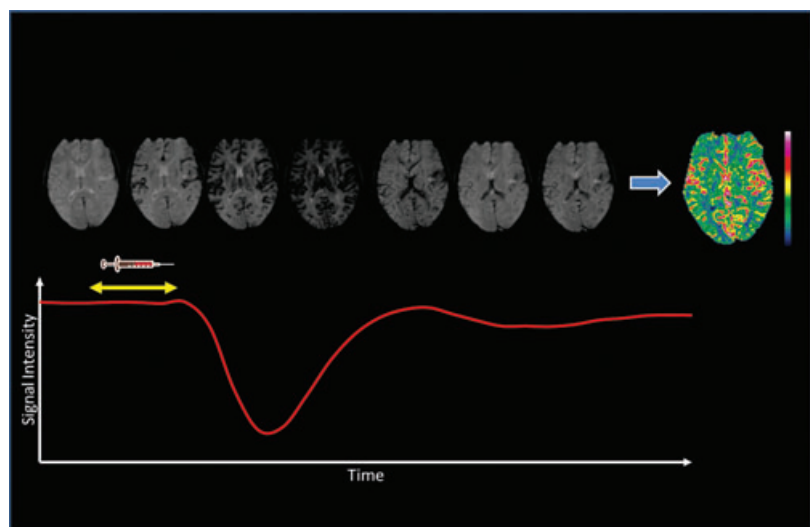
Basic principle of an DSC-MRI perfusion imaging experiment. Bolus injection of a gadolinium chelate results in a dynamic signal drop in the MR image during the passage of the contrast agent. This dynamic signal change can be converted to physiological parameters like relative CBV and relative CBF using established tracer kinetics theory.
